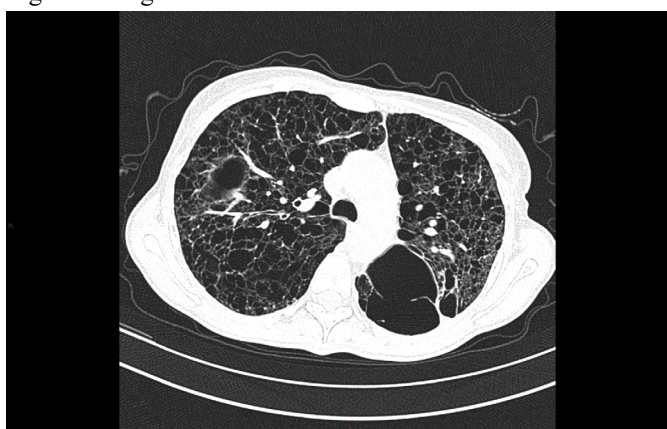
Thoracic CT scan: Pulmonary lymphangiomyomatosis, with cystic lesions and almost no normal lung tissue
